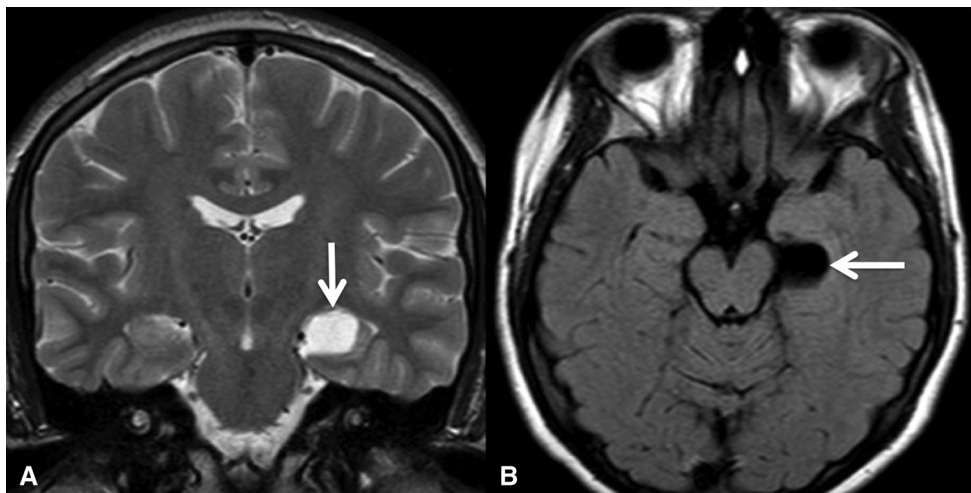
Left choroidal fissure cyst. Coronal T1-weighted (A) and Axial T2 FLAIR images (B) show a cerebrospinal fluid isointense lesion in the left choroid fissure (arrows).
